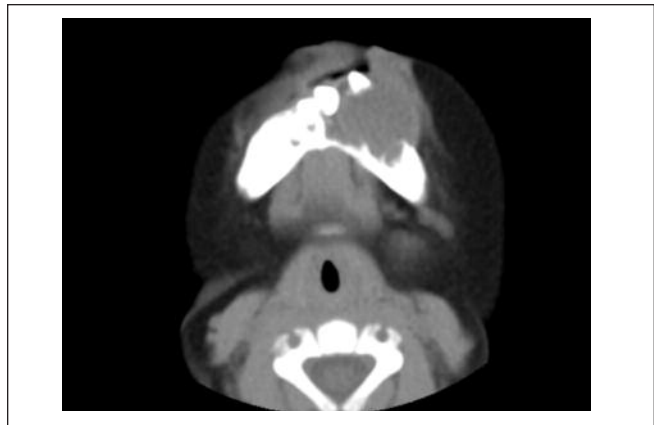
Case 2: Axial soft tissue window Computed Tomography depicts an expansile cystic lesion within the left mandibular anterior region. Thinning of the lingual and buccal mandibular cortex with teeth displacement and soft tissue swelling is demonstrated.
